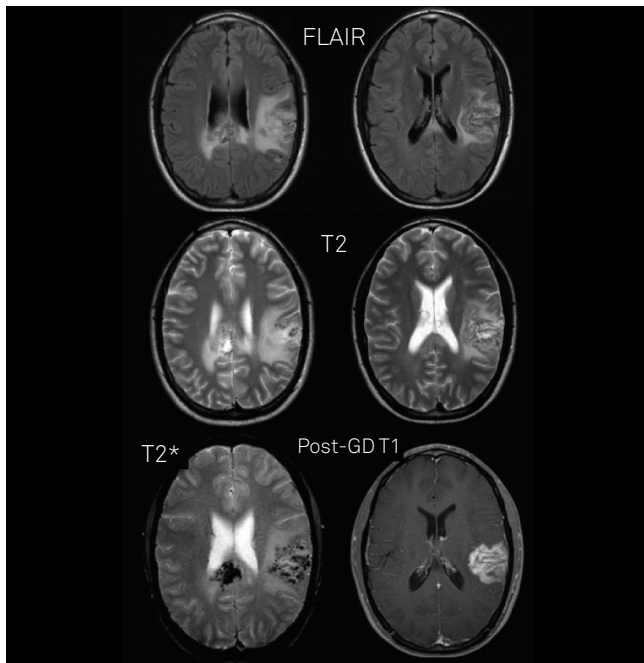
Brain magnetic resonance imaging one month after the onset of clinical symptoms and corticosteroid therapy. Expansive lesions were detected in left cortical/subcortical parietal lobe and in the splenium of the *corpus callosum*. The lesions presented heterogeneous hyperintense signal on FLAIR and T2-weighted images, marked hypointense signal on T2* (blood products), and contrast enhancement (blood brain barrier disruption). Perilesional edema was also noted. The other brain lesions detected presented the same signal intensity (not shown).
